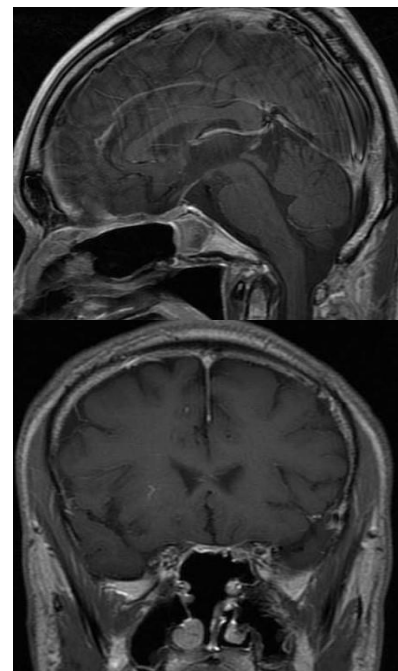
Post-operative MRI sagittal and coronal images showing total excision of tuberculum sella meningioma.
